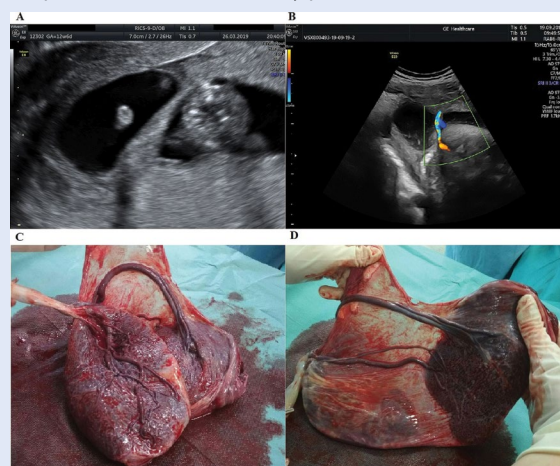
A. 12 weeks of gestation, transvaginal scan. Anterior and posterior placental lobes with visible band/septum. Fetus on the right (neck area); B. 38 weeks of gestation, transabdominal scan. Anterior and posterior placental lobes with visible vessels in Doppler imaging; C. 38 weeks of gestation, bilobed placenta with atypical cord insertion (large caliber vessels) after cesarean section; D. 38 weeks of gestation, bilobed placenta with atypical cord insertion (large caliber vessels) after cesarean section — different perspective
